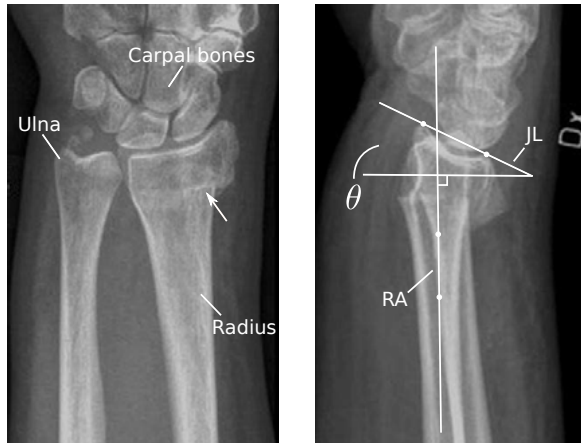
Left: frontal X-ray image of a fractured radius bone. The arrow marks the fracture location. Right: the fracture angulation θ , measured in 2D on a lateral X-ray image of the same wrist. θ is defined as the angle between the joint line JL and a line that is orthogonal to the long-axis RA of the radius.
